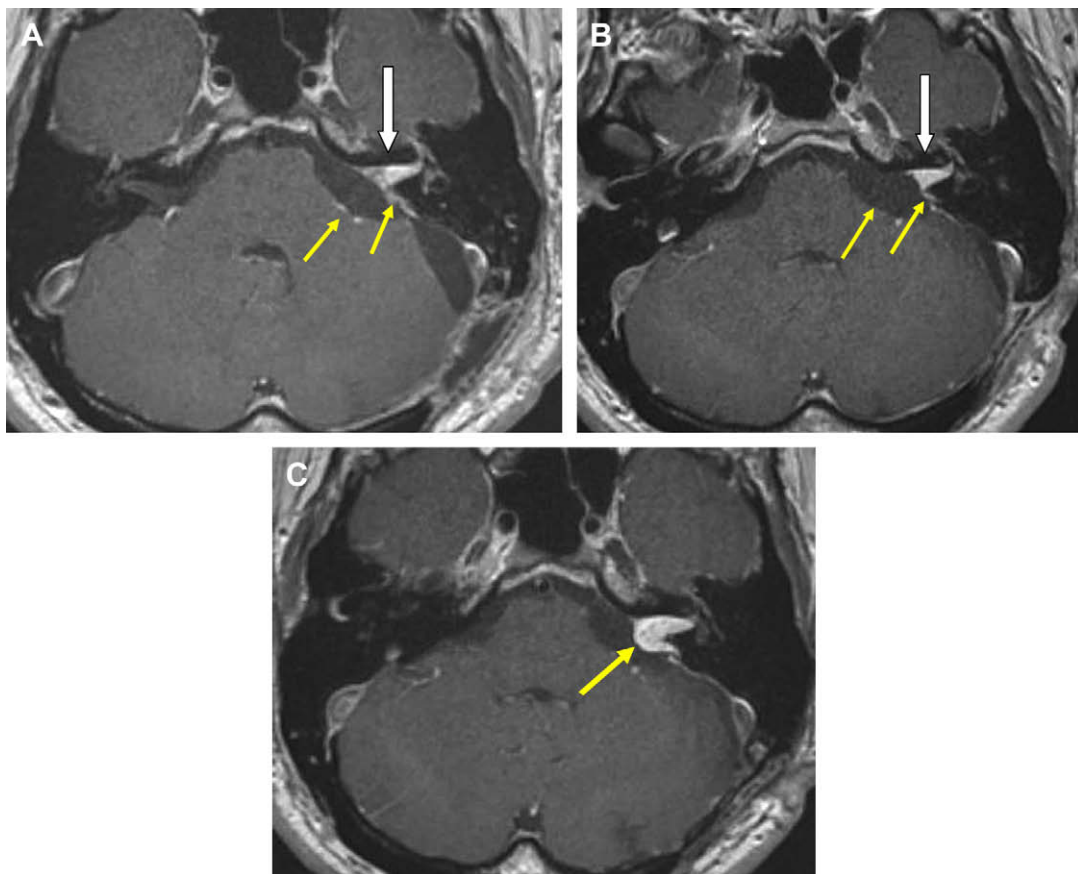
(A) Axial postcontrast T1-weighted image 6 months following surgery (RS approach for AS) demonstrates solid enhancing tissue filling the IAC (*white arrow*). The appearance is indeterminate regarding postoperative change, graft, or tumor. Note thinner linear enhancement along the brainstem and posterior to the widened porous (*yellow arrows*). (B) Same patient but 12 months following surgery. The linear enhancement has diminished (*yellow arrows*). The enhancing tissue filling the IAC (*white arrow*) appears slightly smaller, the medial margin now concave (previously flat). Findings were interpreted as postoperative change without tumor. (C) Same patient 24 months after surgery. Note that the tissue filling the IAC now has a convex medial margin and is beginning to bulge into the CPA (*arrow*). Findings consistent with progressive residual tumor.
